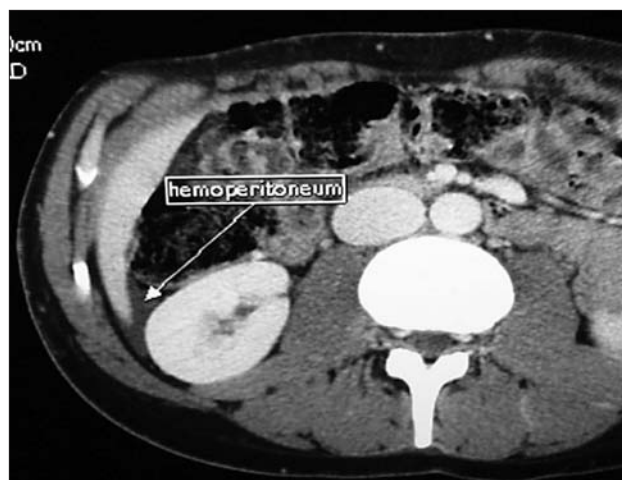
CT scan without contrast showing hemoperitoneum secondary to above liver laceration.
